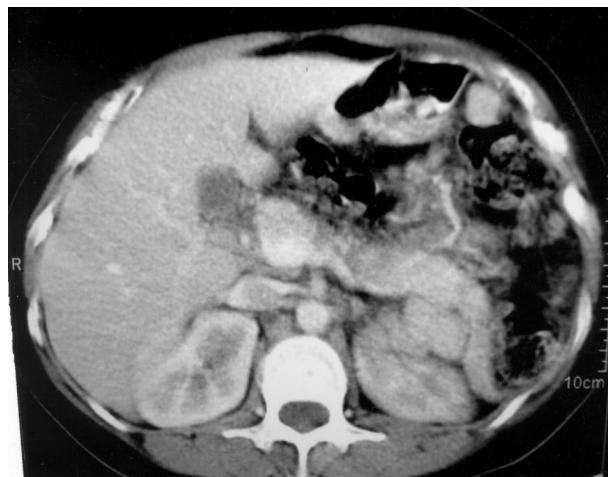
Computed tomography appearance of ectopic splenic tissue.
